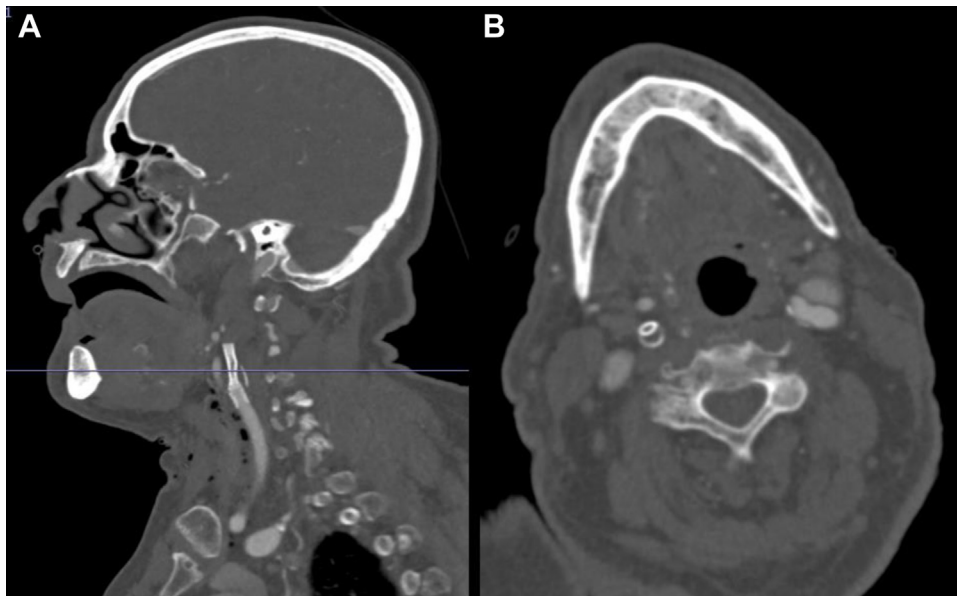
Immediate postoperative computed tomography angiogram of the head and neck demonstrating right internal carotid artery (ICA) stent occlusion after initial transcrotid artery revascularization (TCAR). A, Sagittal image selected to demonstrate lack of contrast opacity within the distal stent compared with the common carotid artery (note: not center-lined). B, Axial image demonstrating the occluded portion of the stent with the most apparent narrowing; however, it was not significantly narrow (<50%) compared with the distal aspect of the stent within the ICA.
